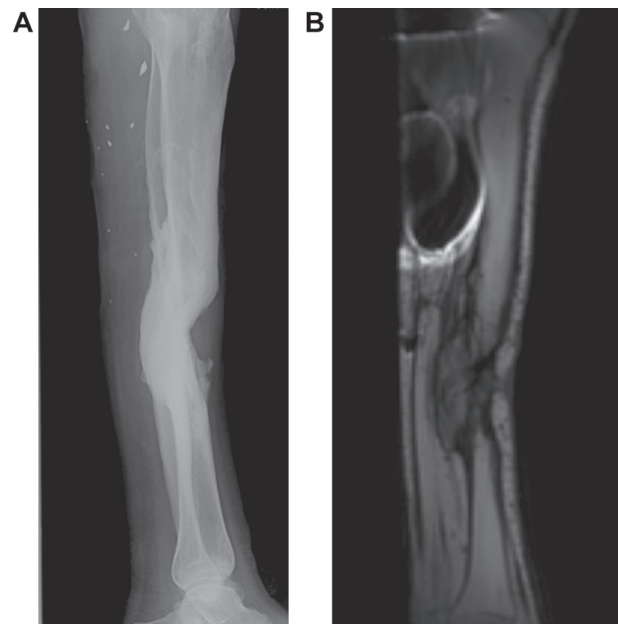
A. Multiple metal fragments in the calf as well as bone deformation are evident on the lateral radiographs of a 56-year-old male with a combat injury sustained 30 years earlier. B. T1-weighted sagittal MRI of the same area with an artifact resulting from the fragments. No adverse sensation was reported during or after the exam.
